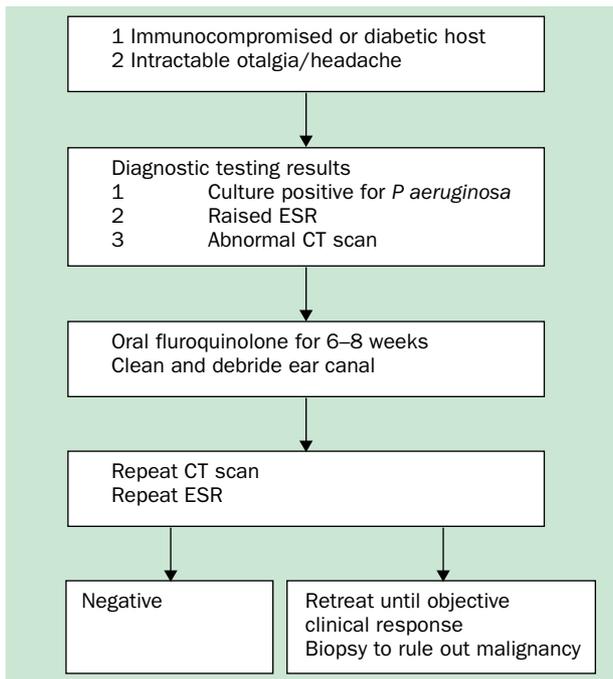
Diagnostic and treatment algorithm for malignant external otitis. The approach is based on obtaining a history to identify a high-risk patient, and on focused laboratory testing including ESR, culture, and radiography.
